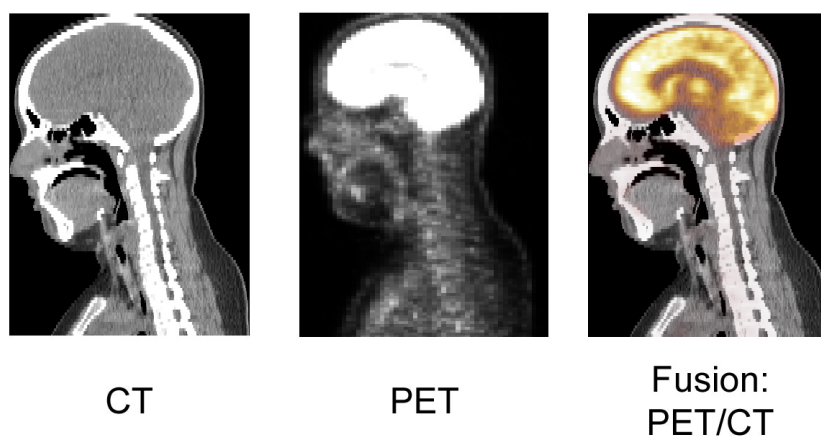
Example of a ^{18}F -PET/CT fusion image.
